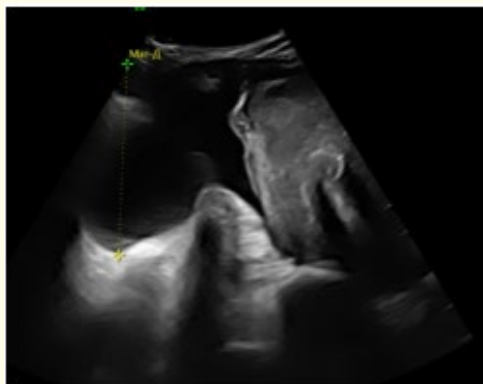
Ultrasound image: presence of large amounts of fluid in the pelvis and abdominal cavity.
